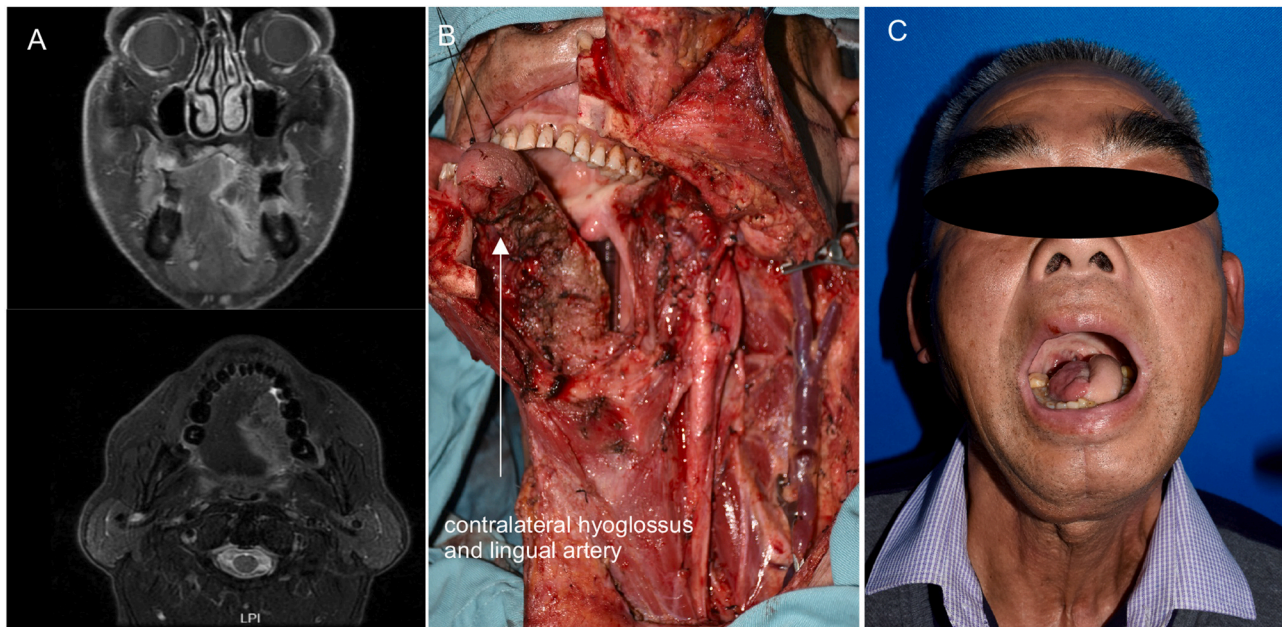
Primary tumour suspected to have invaded the contralateral MGC. (A) MRI of the primary tumour. (B) The contralateral hyoglossus and lingual artery were preserved after resection of the contralateral MGC. (C) Appearance at 24 months after surgical treatment. (MGC, musculus verticalis linguae–genioglossus complex.).
